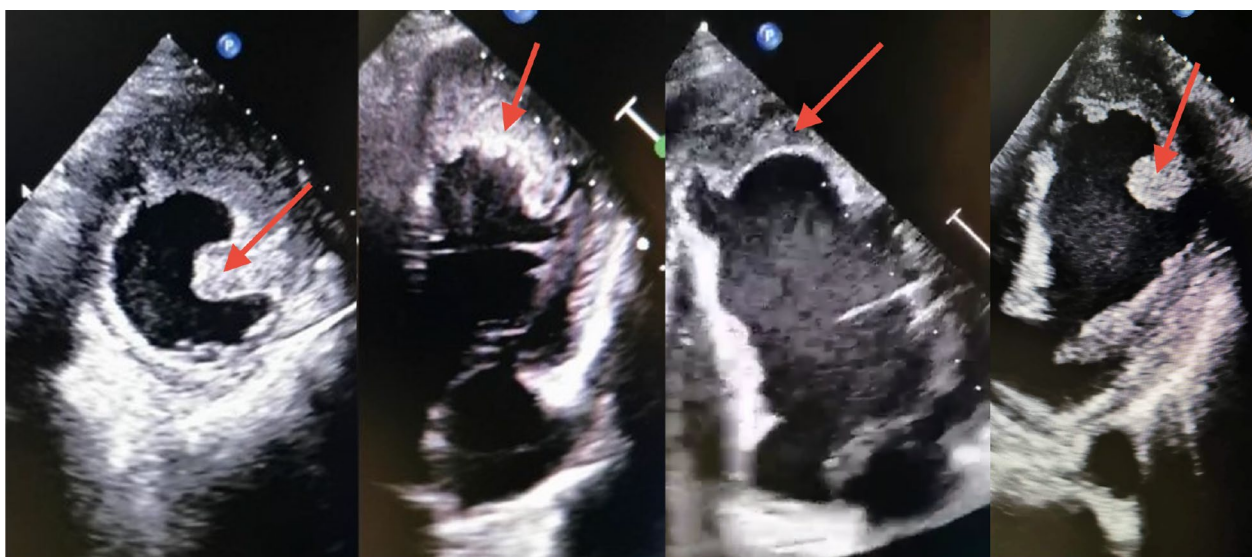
Transthoracic echocardiography images of patient 2 on admission; the thrombus is marked with arrows
